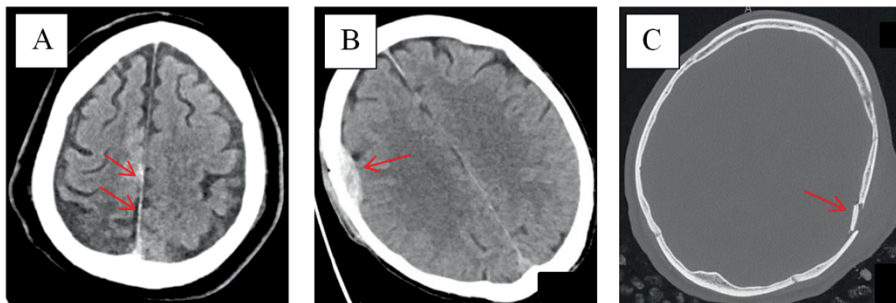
Example traumatic intracranial CT findings
